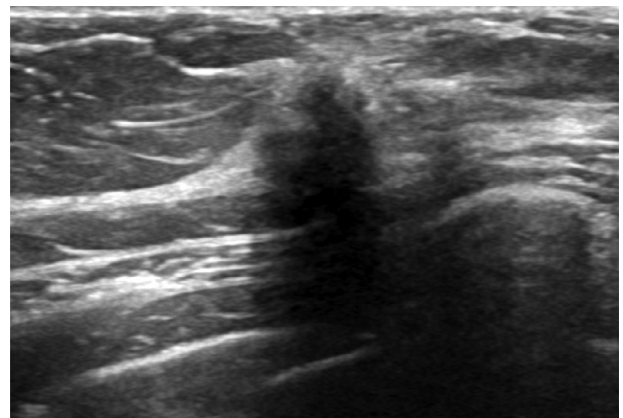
Targeted ultrasound of the left breast demonstrates a solid, irregular mass with indistinct margins in the upper outer quadrant, which corresponds to the focal area of nonmass enhancement on MRI.
